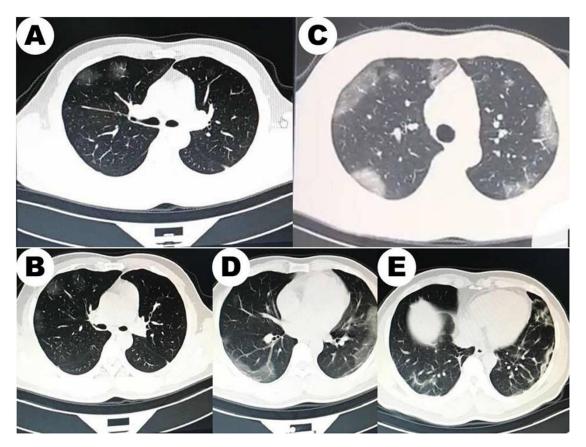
Chest imaging of the patient. (A-B) Chest CT scans of the lung on January 30 and January 31, 2020 (3-4 days after the symptom onset) slight pulmonary infiltration. (C-D) The CT scans taken on February 03, 2020 (8 days after the symptom onset) obvious pulmonary infiltrates. (E) The CT scans taken on February 10, 2020 (15 days after the symptom onset). CT: high-resolution computed tomography.
